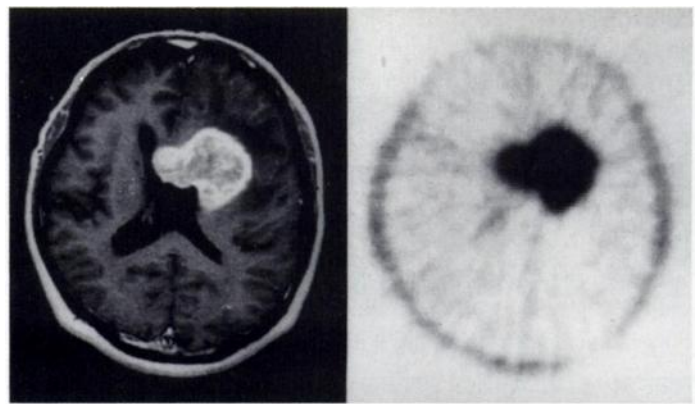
Case 1, brain tumor (glioblastoma multiforme); MRI with enhancement (left) and PET with [^{11}C]choline (right). Tumor/normal brain [^{11}C]choline uptake ratio, 13.4; tumor/normal brain CBF ratio, 1.7.
